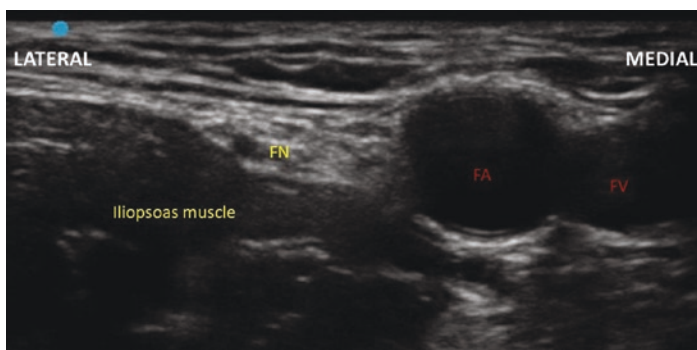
Femoral nerve ultrasound. Femoral Nerve (FN) seen lateral to the Femoral Artery (FA) and Femoral Vein (FV)
